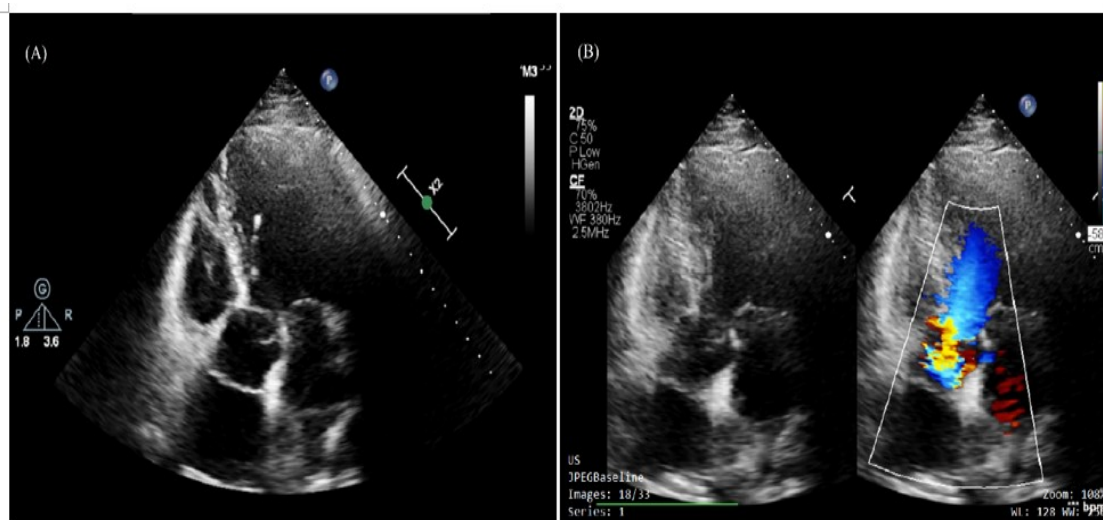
Transthoracic echocardiography. (A) Apical five chamber view: showing dilated aortic with intimal flap just above the aortic valve level. (B) Color Doppler imaging showing mild aortic regurgitation and identified the true lumen and false lumen.
